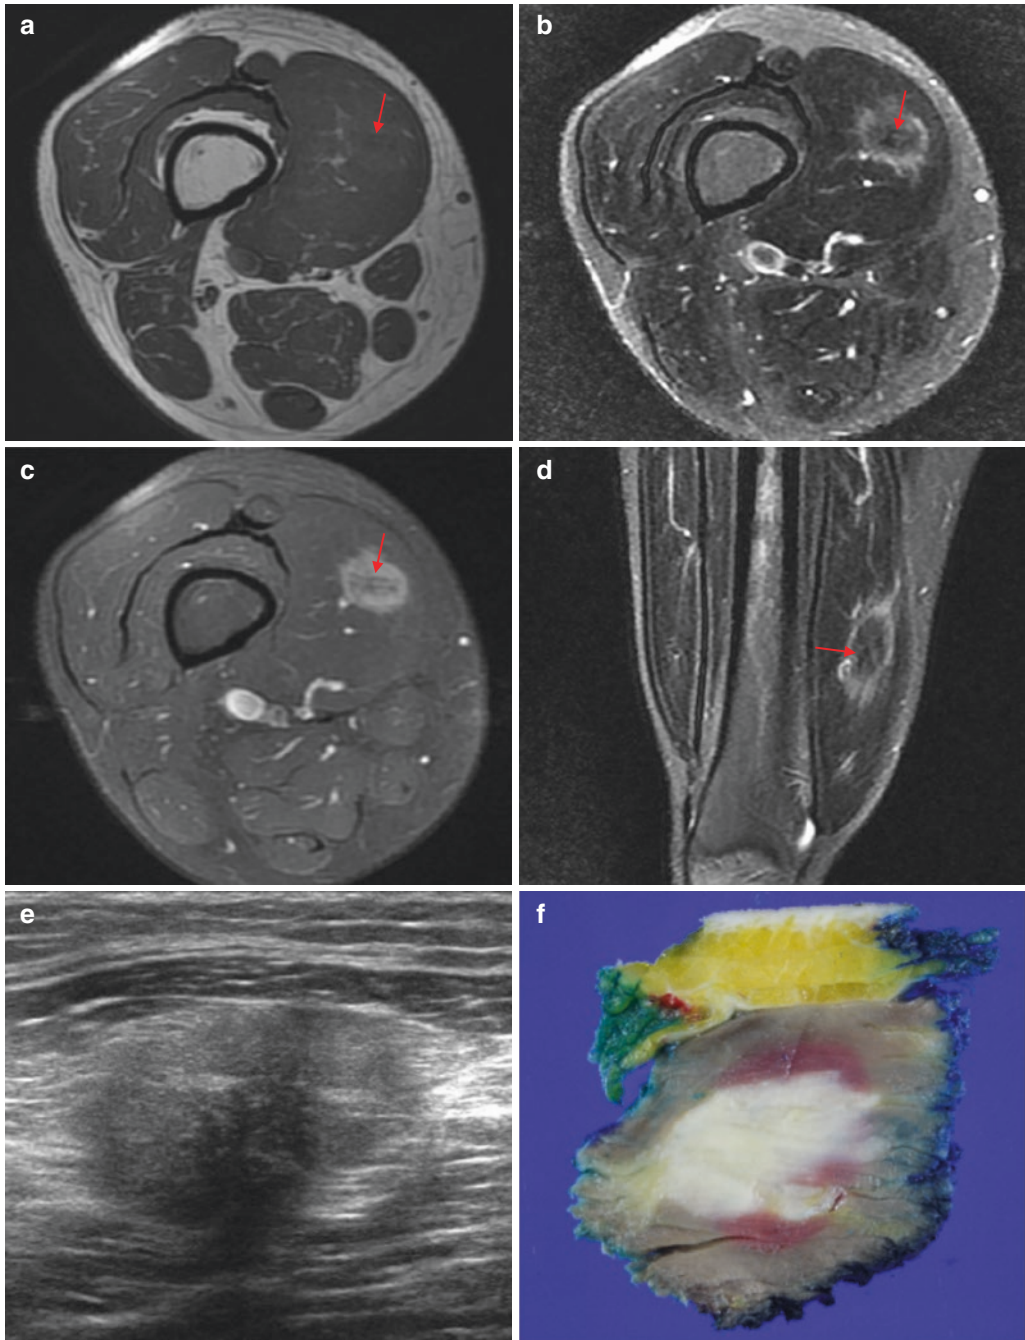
Granular cell tumor. MR images of the thigh show an irregular, speculated bordered soft tissue mass within the vastus medialis muscle. The lesion is isointense to muscle on T1WI (a), central heterogeneous hypo/isointensity and peripheral hyperintensity on T2WI (b), and inhomogeneous enhancement on postcontrast FS T1WI (c). Coronal FS T2WI (d) reveals an intermediate signal ovoid mass with irregularly marginated, peripheral T2
